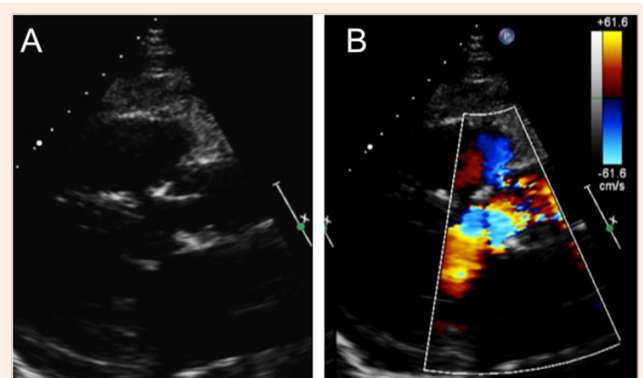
Parasternal long axis transthoracic echocardiogram (A) demonstrating thickened aortic valve leaflets with a stenotic valve on colour flow Doppler (B).
